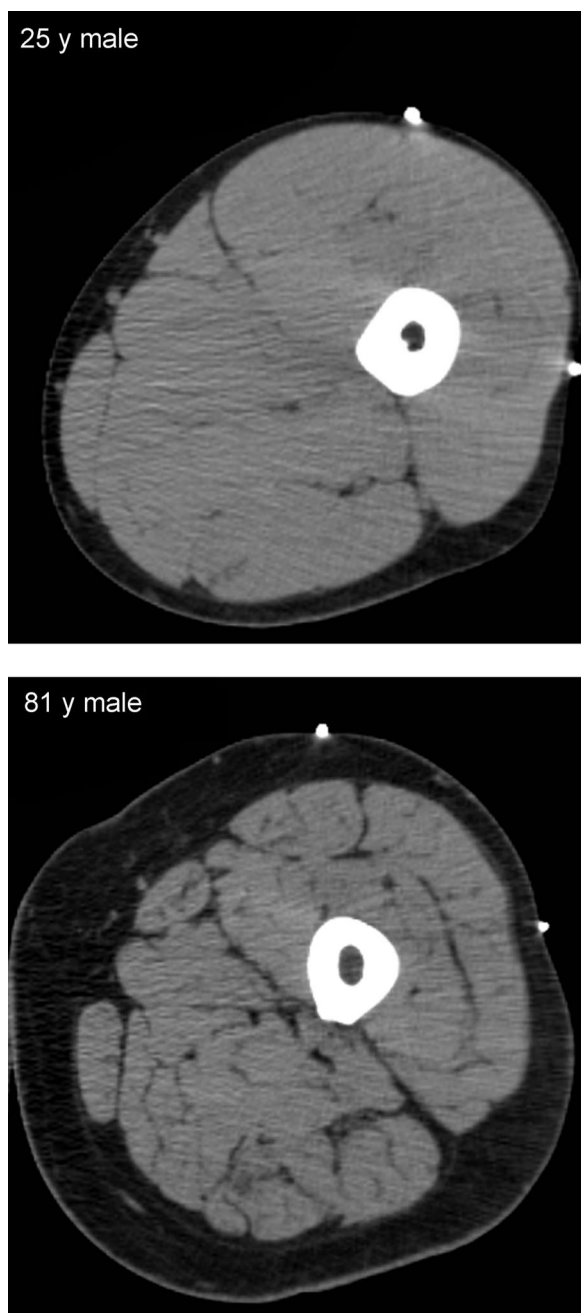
Computed tomography (CT) scan of the upper leg (midhigh level) in a young and old subject, matched for body mass and height. Note the reduced muscle area, increased subcutaneous fat, and increased fat and connective tissue infiltration into the muscle in the elderly subject.
